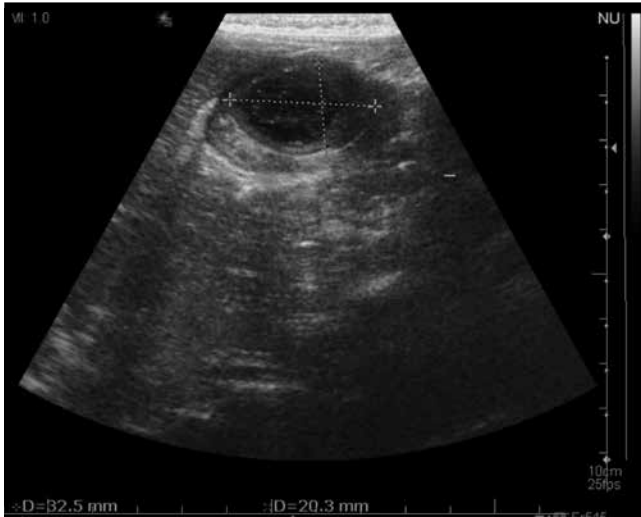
Abdominal ultrasonography showed a thickened wall cystic lesion measuring 32×26×20 mm on the anterior wall of the stomach in the pyloric region
